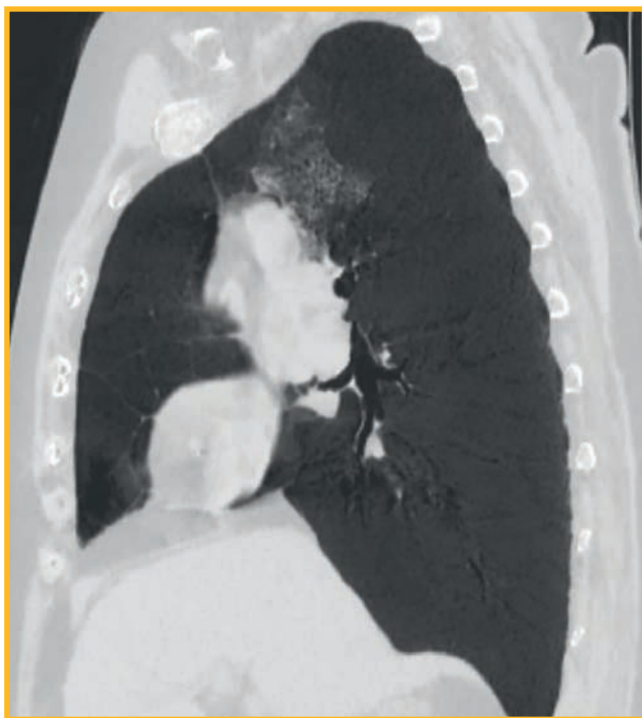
Multispiral computed tomography of the chest (1 mm slices) on the 1st day of clinical symptoms of COVID-19 pneumonia. The sagittal reconstruction in MinIP mode showed extensive lesions in the left upper lobe and the low intensity ground glass opacities in the upper and lower lobes of the right lung
